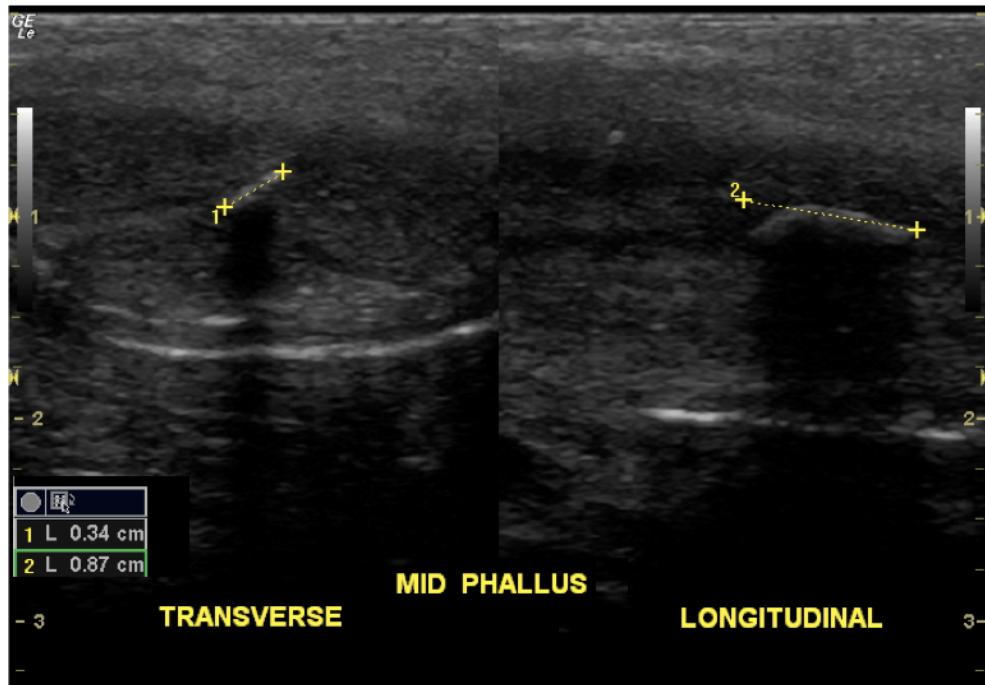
Penile Plaque. Penile ultrasound demonstrating calcified penile plaques (objects 1 and 2 between yellow calipers)
